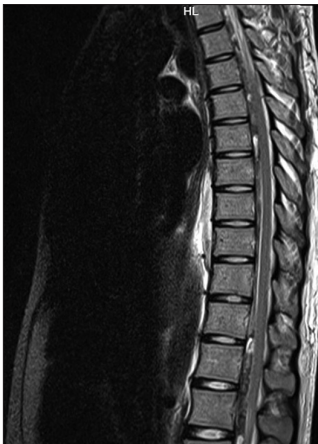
Magnetic resonance imaging dorsal spine sagittal cuts showing epidural haematoma
